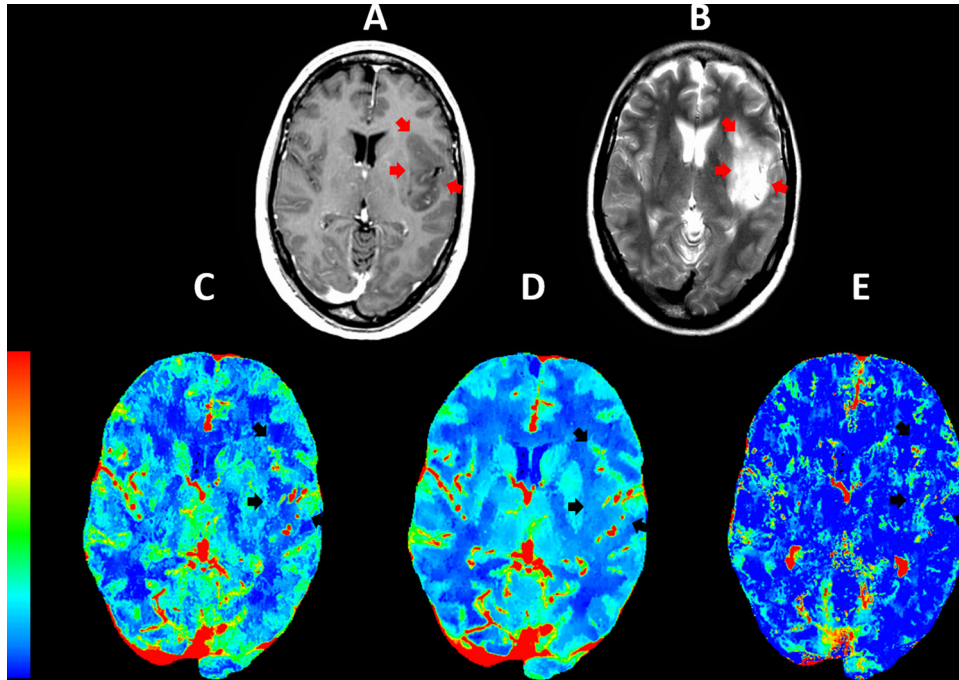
A patient with grade II diffuse astrocytoma. Post-gadolinium T1-weighted image (A) shows a non-enhancing lesion (red and black arrows) with minimal peritumoral edema on T2-weighted image (B). Maps of blood flow (BF), blood volume (BV), and permeability-surface area product (PS) do not show a region of elevated BF, BV, and PS.
